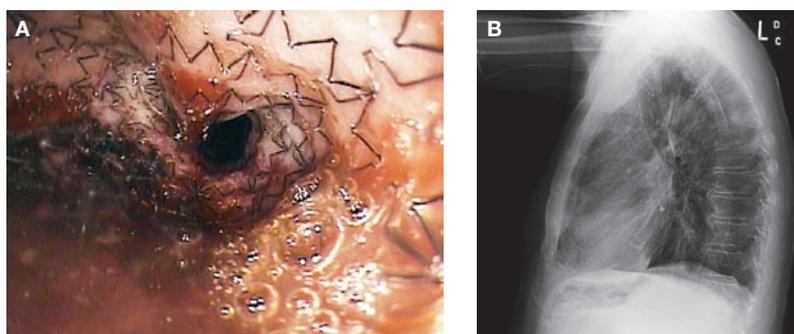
Use of a self-expanding esophageal stent to manage an esophageal stricture. (A) Endoscopic view of a self-expanding stent deployed in the esophagus. (B) Chest radiograph showing the stent deployed in the esophagus.
